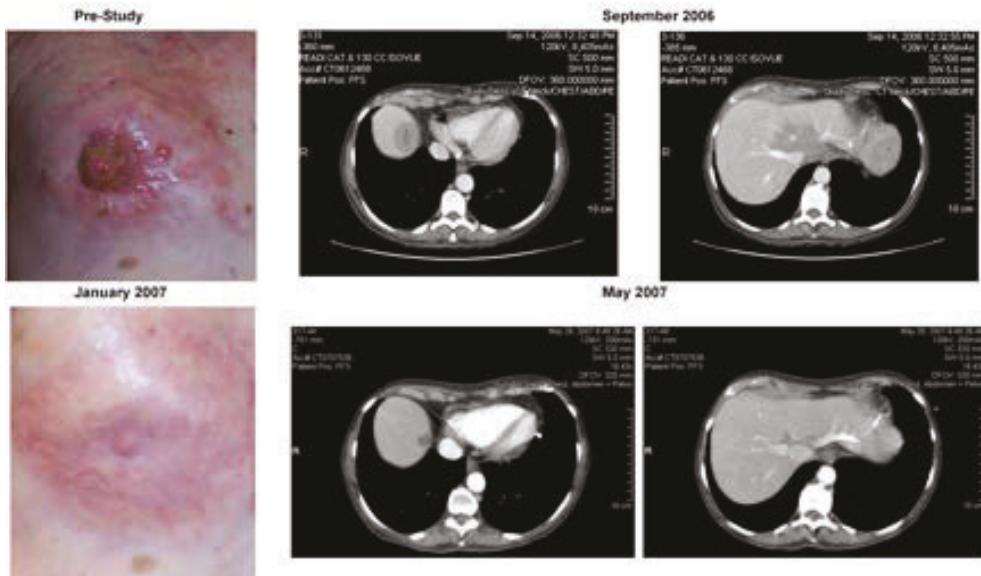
Pre- and post-treatment CT scans of a 61-year-old female with metastatic breast cancer who had received multiple chemotherapy and hormonal regimens including high-dose chemotherapy and autotransplant prior to enrolling on the Phase I trial of FdCyd +THU.
